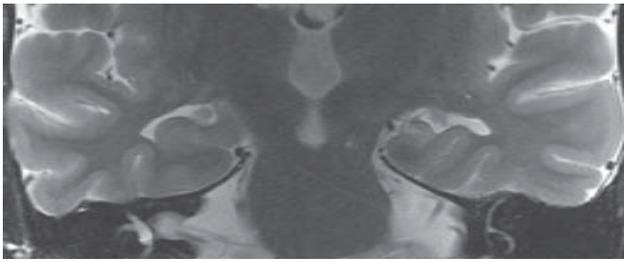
FSE T2 temporal lobe oblique coronal MRI at the level of midbody of hippocampus demonstrates clear hippocampal atrophy and T2 high signal.
